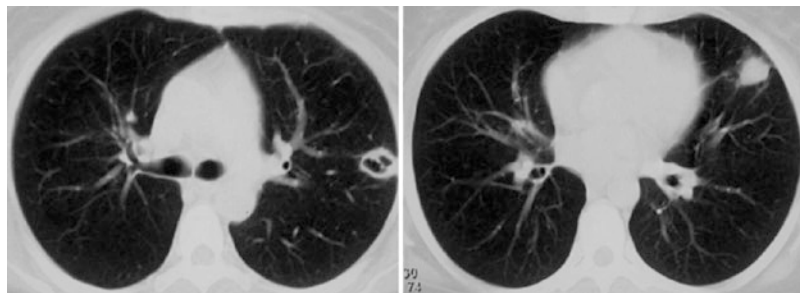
Granulomatous polyangiitis (Wegener's granulomatosis) lung lesions: chest computerized tomography (CT) showing bilateral round opacities with and without
